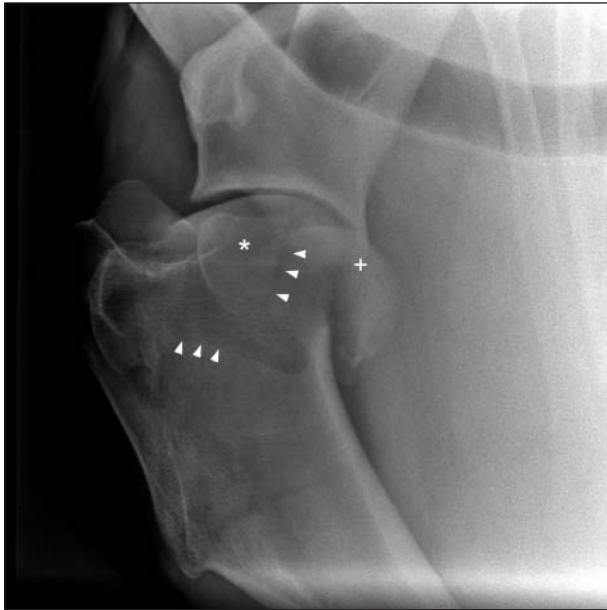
Same radiographic image as in Figure 1. Notice the comminuted parasagittal fracture of the medial head of the humerus (plus sign), involving the lesser tubercle (asterisk). The fragments are displaced caudally and distally. Several fracture lines are evident (arrowheads).
